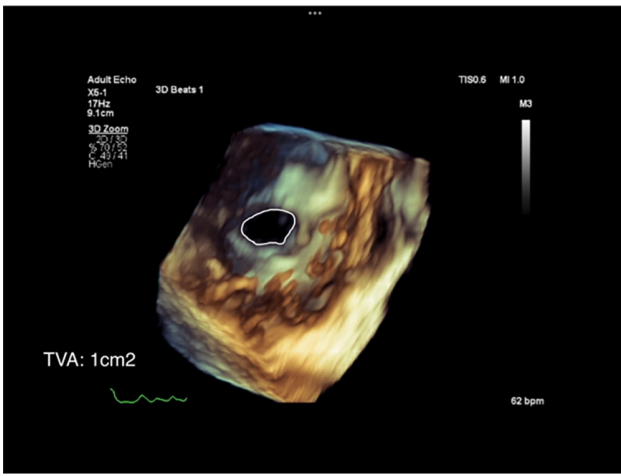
Three-Dimensional Echocardiography Image Revealing Severe Tricuspid Stenosis with Tricuspid Valve Area (TVA) = 1 cm².
